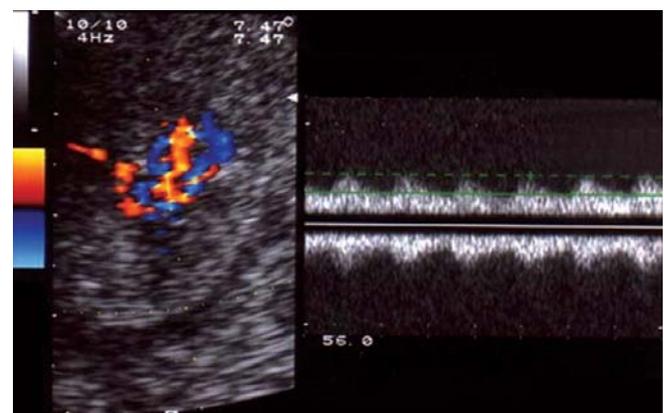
Pulsed Doppler waveform analysis demonstrates low vascular impedance (resistance index, RI of 0.37), consistent with neovascularization
